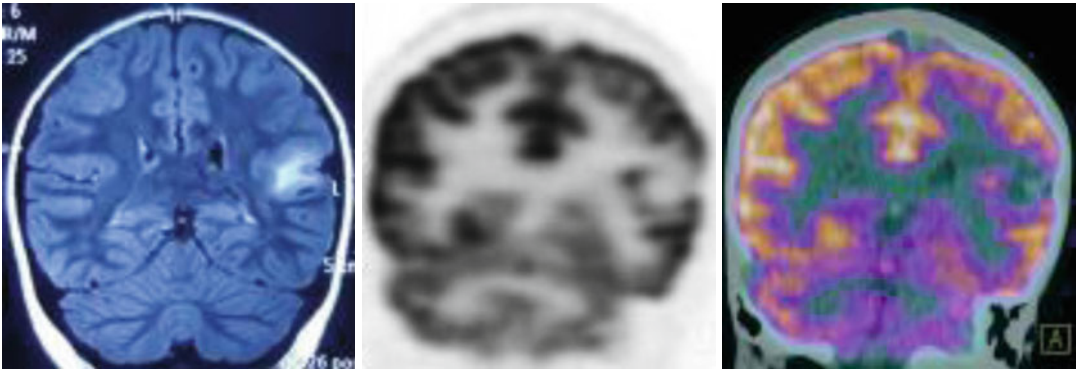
An 11-year-old male child with drug refractory epilepsy. T1 W MRI shows cortical dysplasia in the left parietal lobe. Plain ^{18}F -FDG PET and fused PET-CT images show hypometabolism corresponding to the lesion on MRI
